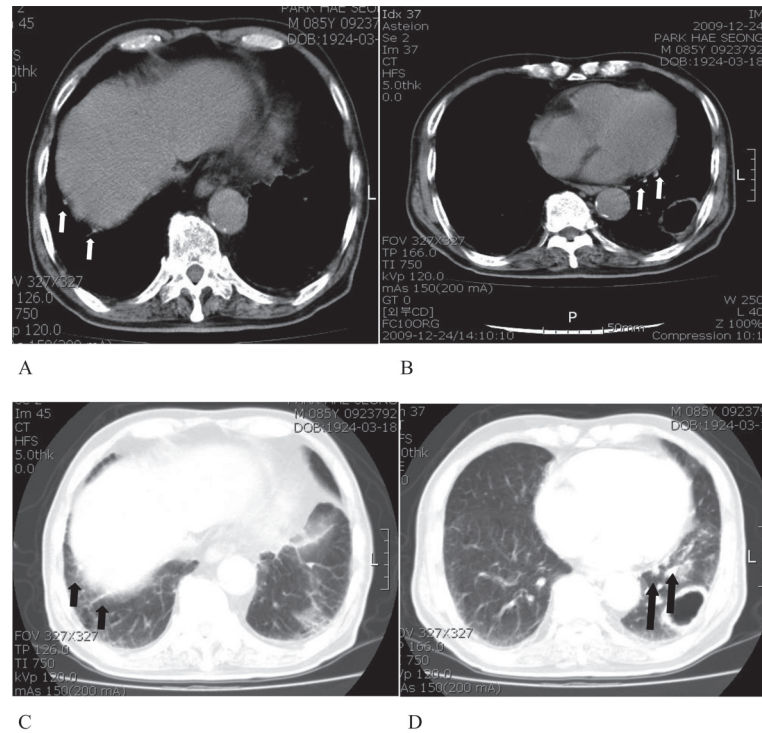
Non-contrast CT shows (A, C) multiple plaques on the diaphragmatic pleura in the right lower lung (arrow heads) (B, D) on the mediastinal pleura in the left lower lung (arrow heads).
